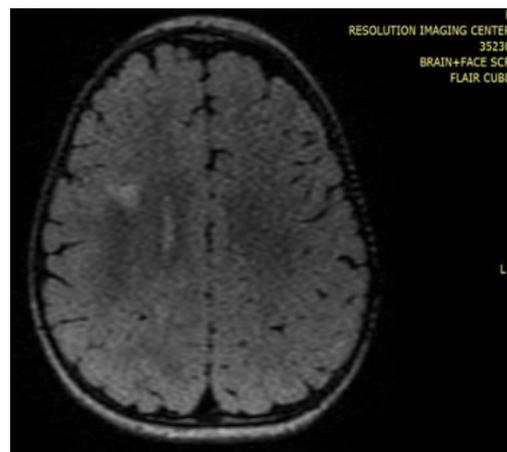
Adjacent FLAIR hyperintense white-matter edema in the right frontal lobe.
